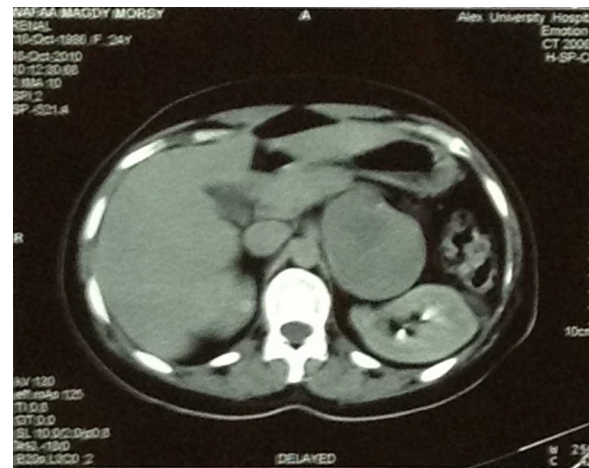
CT image showing a recurrent large left suprarenal tumour.
